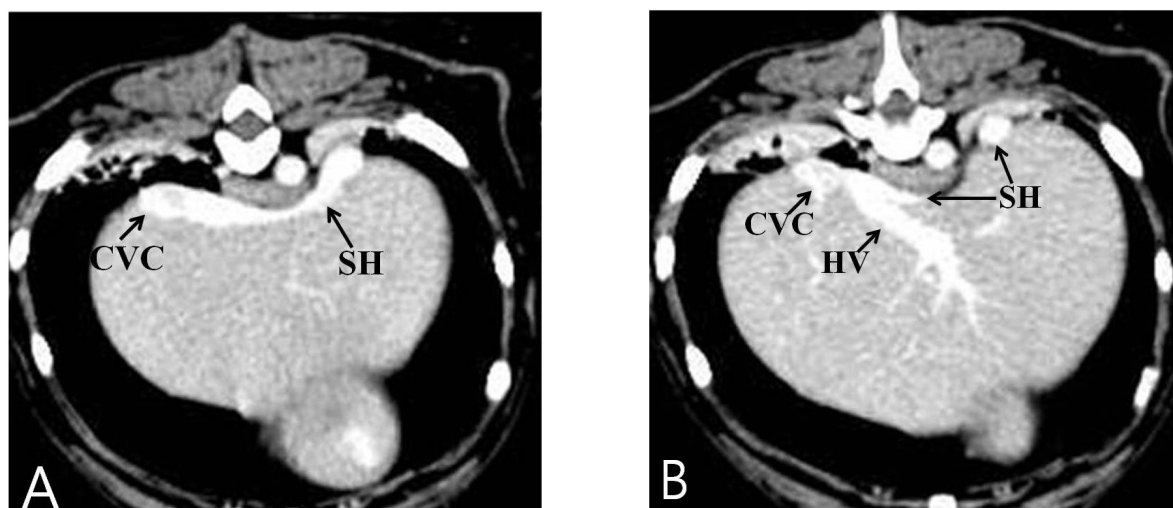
Preoperative transverse computed tomography angiography image after *i.v.* injection of iohexol: The patient's right is on the left in all images. The large shunting vessel passes cranial to the liver along the diaphragm and inserts into the caudal vena cava from the left side (A). The large hepatic vein enters this shunt from its ventral aspect, near where the shunt inserts on the caudal vena cava (B). CVC = caudal vena cava; SH = shunt; HV = hepatic vein
